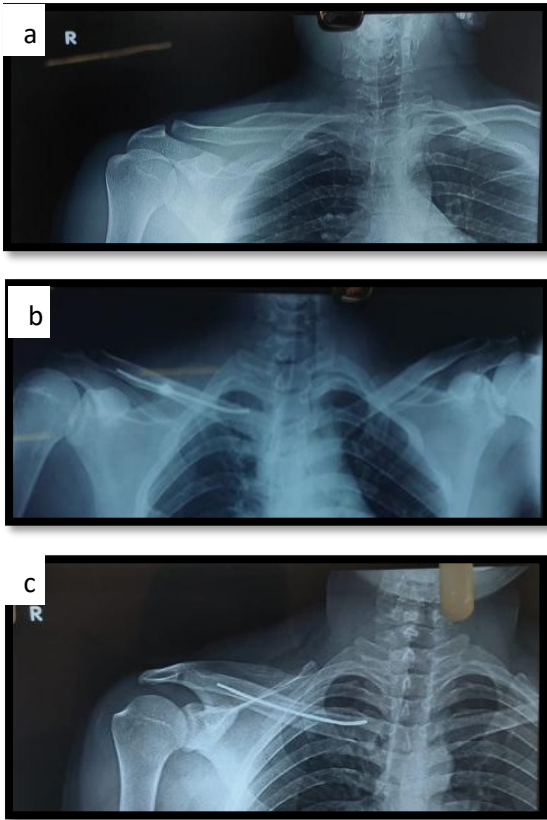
(a-c): Pre-operative X-ray of a 39-year-old male with right sided mid shaft clavicle fracture following road traffic accident. Post-operative X-ray showing fracture fixation done with TENS nail. 16 weeks post-operative X-ray showing satisfactory union with nail in situ.
